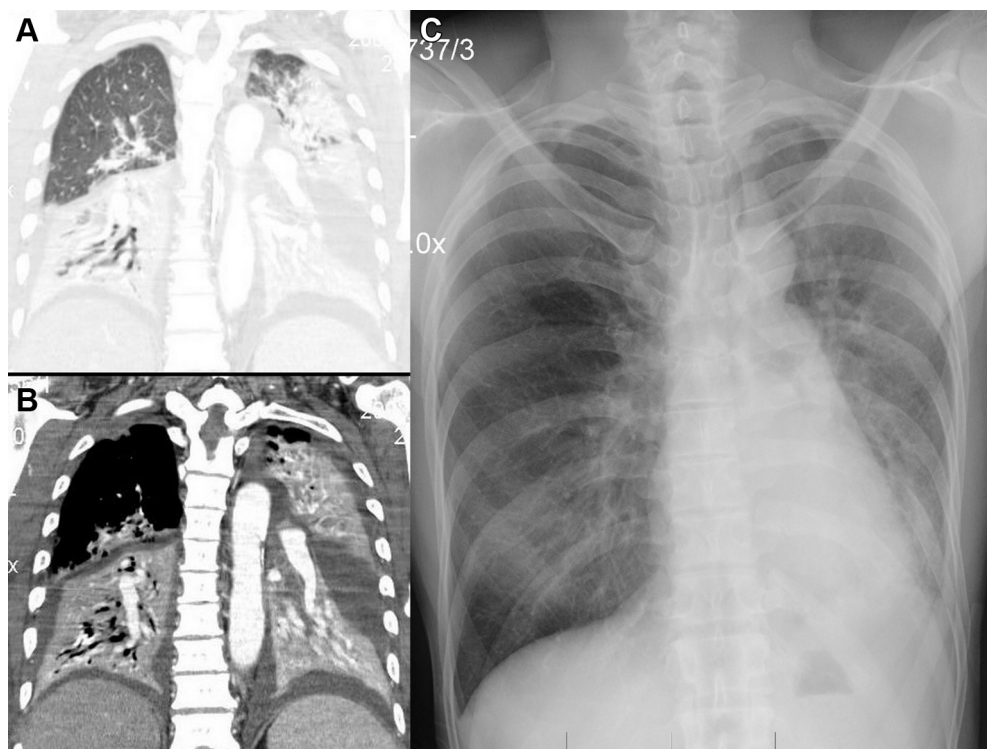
Coronal CT scans (A, B) of the chest in a patient in the ICU with bilateral lower lobe and left upper lobe atelectasis with interval resolution of right lower lobe and left upper lobe atelectasis and improvement without resolution of left lower lobe atelectasis shown in a follow-up chest radiograph (C). The patient was treated without bronchoscopy.
